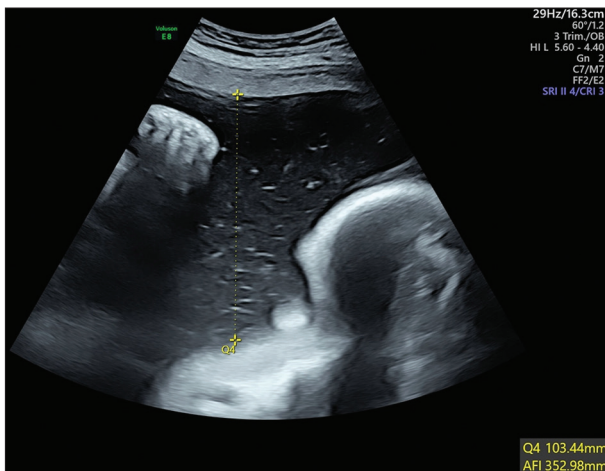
Third-trimester ultrasound: Polyhydramnios
